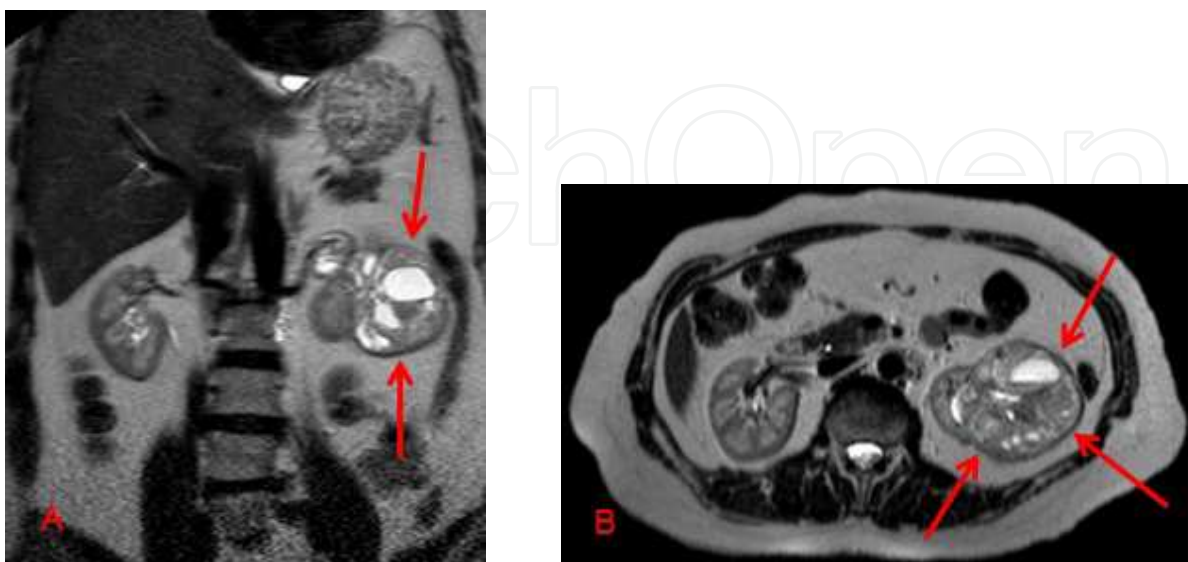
A,B: MRI T2W coronal and axial images show a heterogeneous semisolid cyst hydatid lesion (Gharbi type 4, WHO CE4) with hyperintense cystic areas located at the left kidney.
